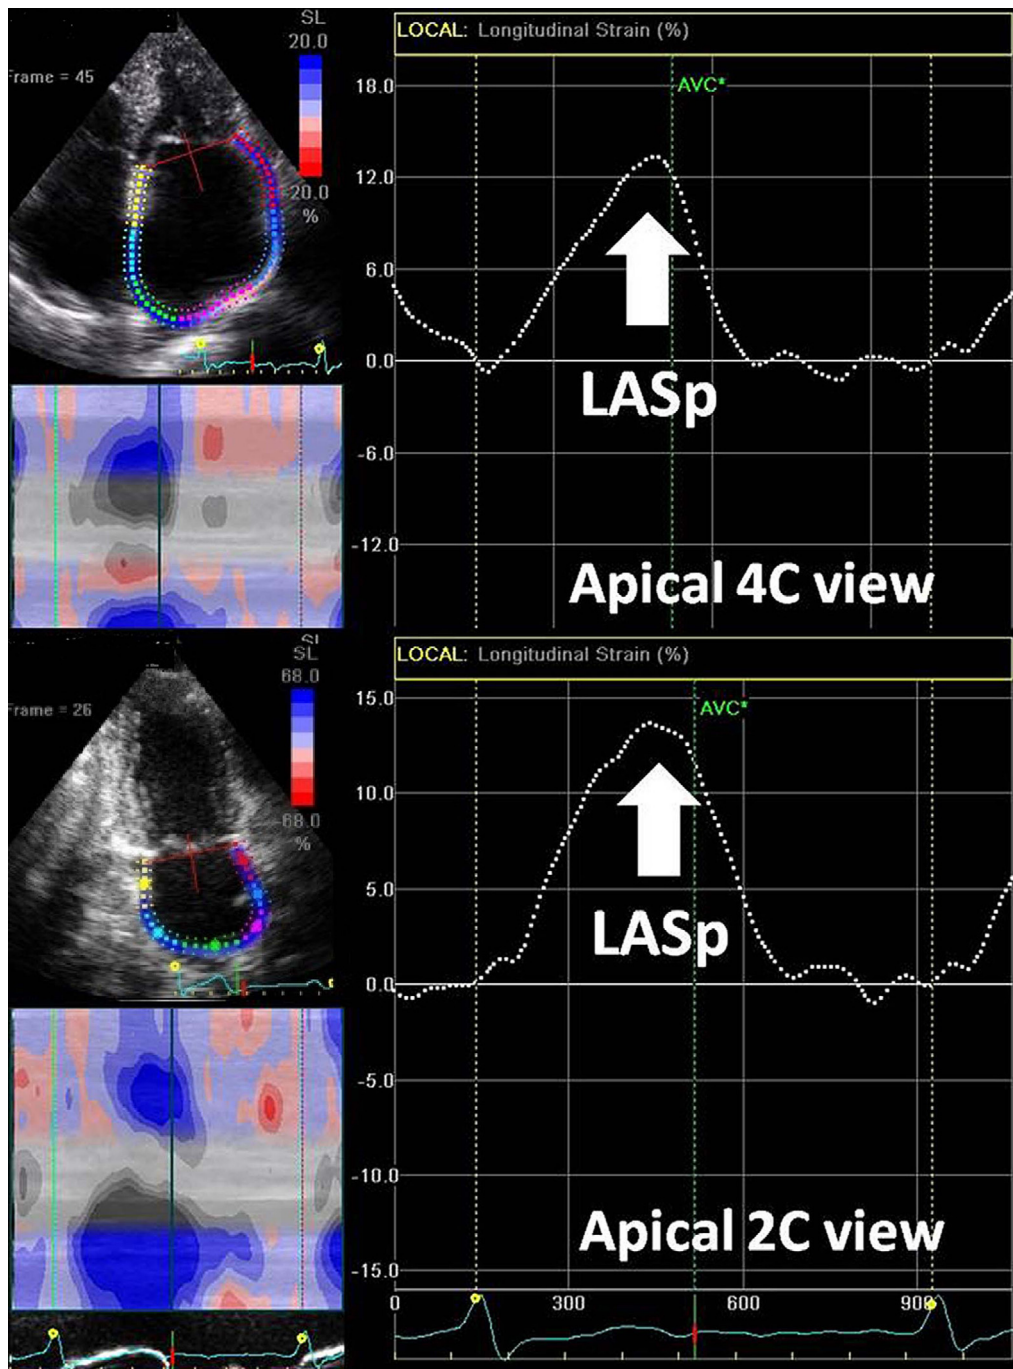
The strain curve from speckle tracking echocardiography of the left atrium in atrial fibrillation patients. Speckle tracking can be obtained from both apical four-chamber and two-chamber views. White arrows indicate LASp, LA: left atrial, LASp: left atrial speckle tracking.
